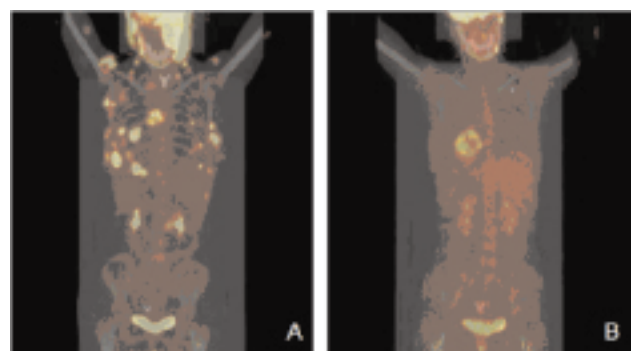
18F-FDG PET indicated that the FDG uptake of the tumor was decreased remarkably and the patient obtained partial remissions after 2 cycles of chemotherapy. A: Before chemotherapy (Aug.7th, 2009); B: After chemotherapy (Sep. 30th, 2009).
